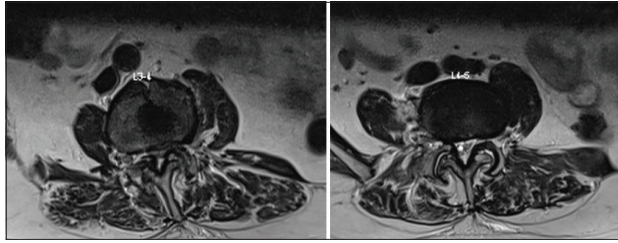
Preoperative axial magnetic resonance imaging sections at L3-L4, L4-L5 showing severe canal stenosis at both levels, more at L3-L4 of patient 2.
